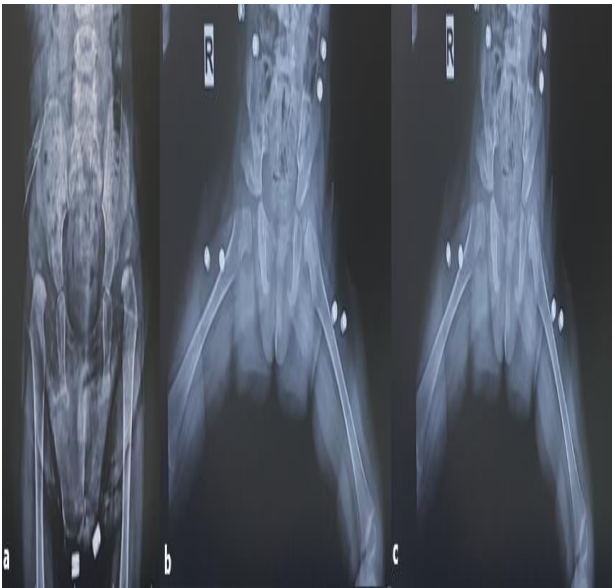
An 18-month old female patient applied with open reduction + Pemberton acetabuloplasty (a-Preop,b-Postop 3rd month,c-Postop 1st year radiographs)
